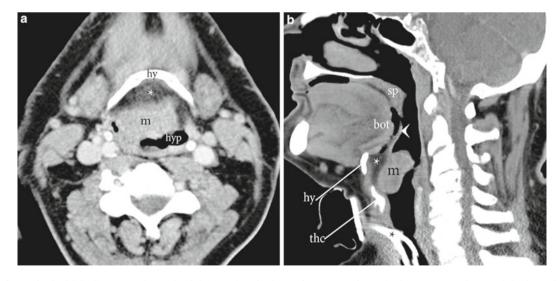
Supraglottic SCC. Contrast-enhanced axial (a) and sagittal (b) CT demonstrates a mass (m) inseparable from the base of the epiglottis, protruding into the laryngeal vestibule and supraglottic airway. Axial images suggest early extension into the pre-epiglottic fat
